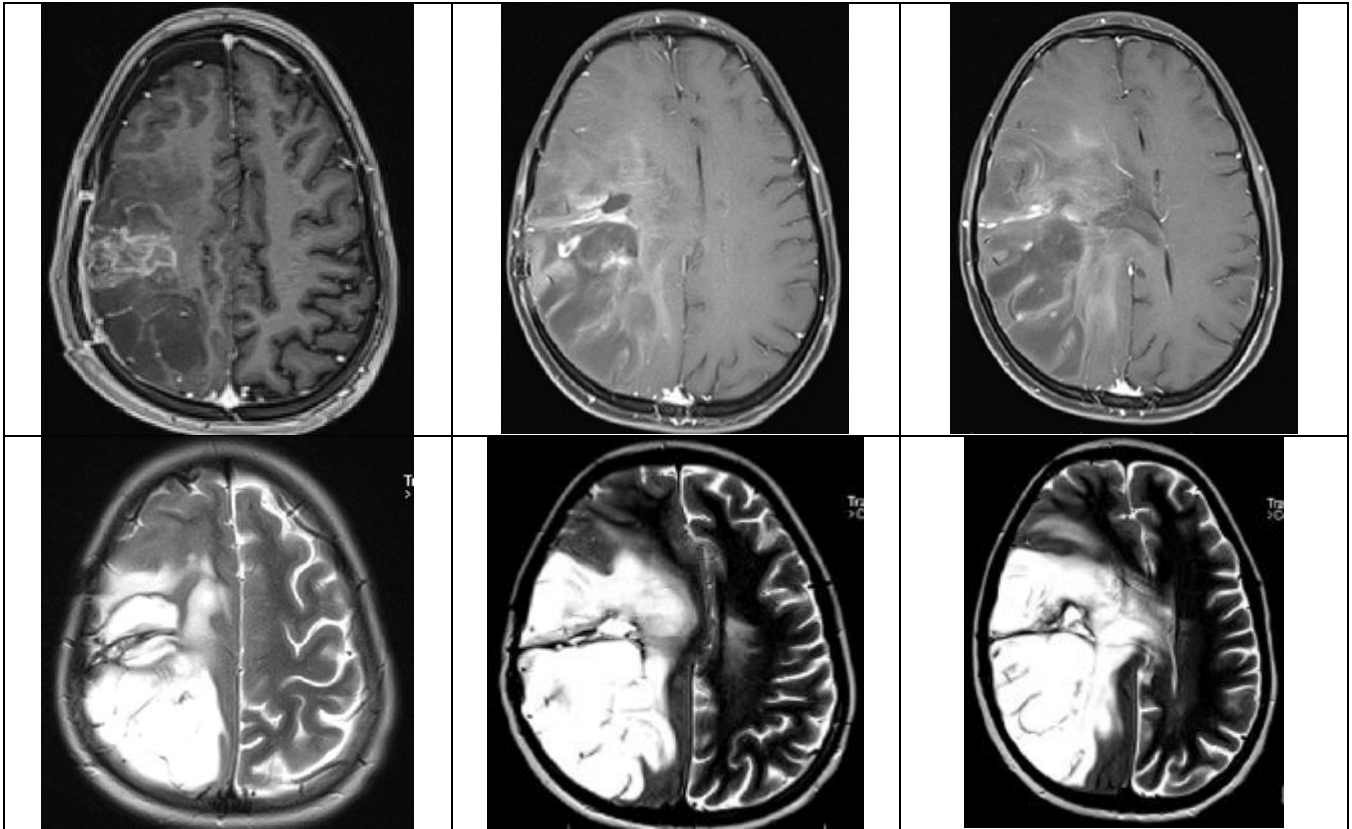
Follow-up brain MRI showing a reduction in the size of the necrotic-hemorrhagic component of the previously identified right frontoparietotemporal tumor. The lesion remains composed of tissue, hemorrhagic, and cystic components with internal septations, demonstrating isointense signal on T1- and T2-weighted sequences and heterogeneous post-contrast enhancement. There is progression of cortical tumor infiltration, predominantly in the right frontoparietal region, extending into the right corona radiata and crossing the midline via the corpus callosum. Ipsilateral extension along the corticospinal tract to the level of the pons is noted, associated with midline shift
